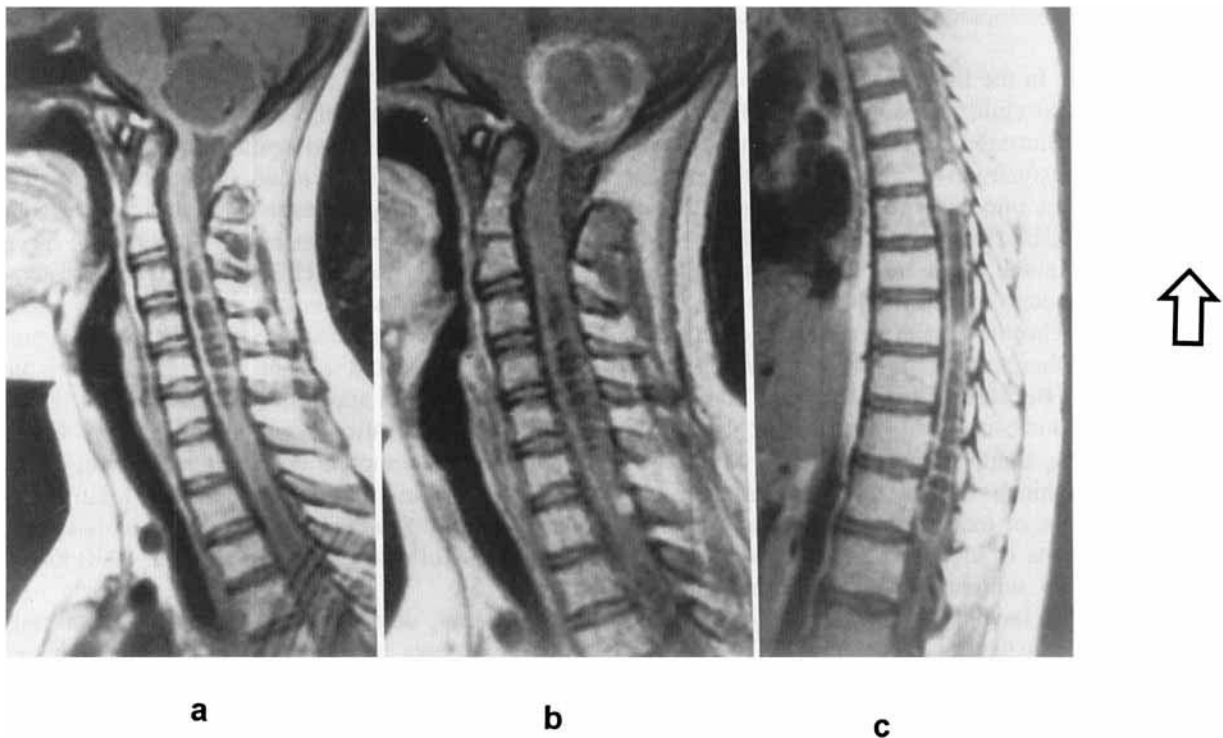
Cervical and thoracic spine MRI-T1 weighted images before (a) and after (b,c) gadolinium enhancement. A large multiseptated syrinx involving the whole spine is visible. Many enhancing nodules are visible along the subarachnoidal space as well as within the syrinx, the largest one being located at the level of T₅-T₆ (c).
